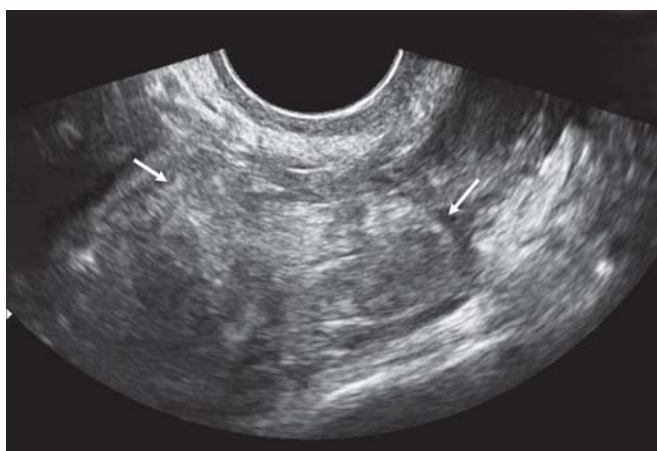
Transvaginal ultrasonography showing inhomogeneous hyperechoic mass (white arrows) in the right adnexa
